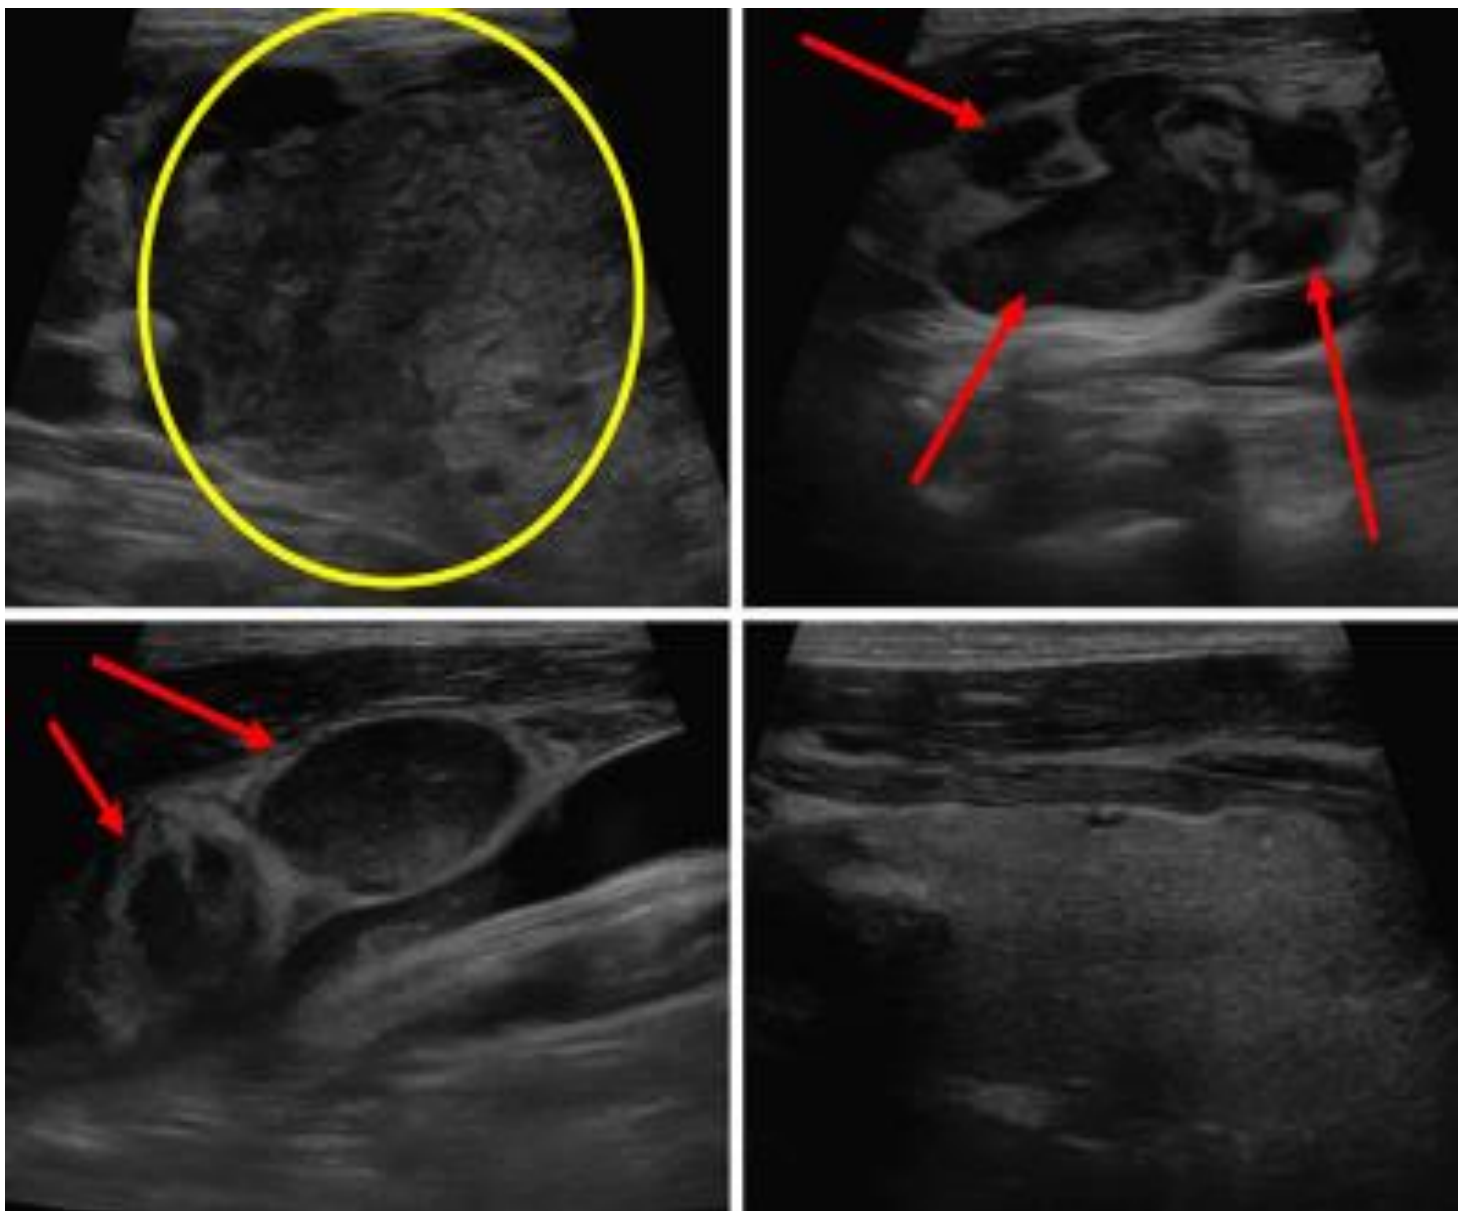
Ultrasound of the neck, long-axis view. (a): Right lobe of thyroid with heterogenous mass (yellow circle); (b): Morphologically abnormal lesions in the level 3 lymph nodes of the right side of the neck (red arrows); (c): Morphologically abnormal lesions of level 3 and level 4 lymph nodes on the right side of the neck (red arrows); (d): Normal appearance of the left thy-roid lobe.
